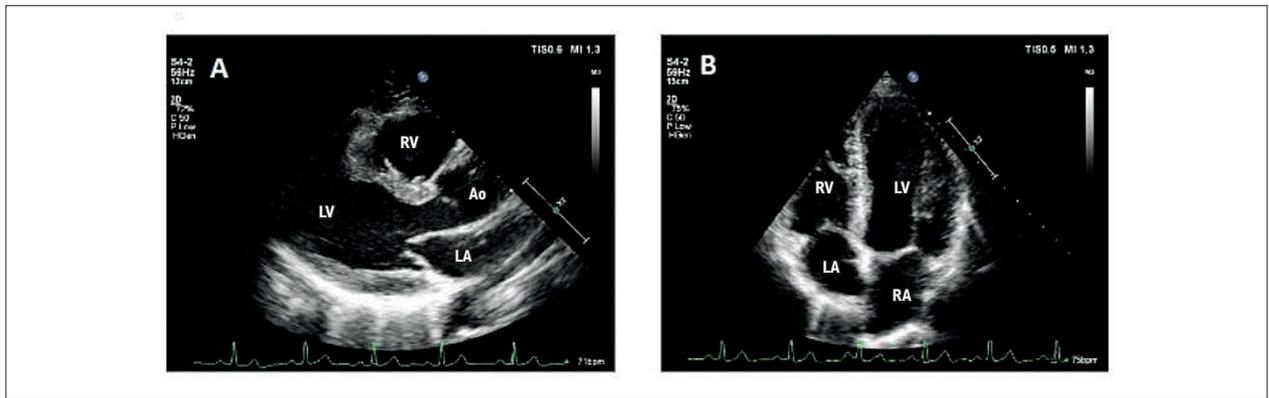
Echocardiographic images in sections: A) Parasternal longitudinal; B) Apical four-chamber view. Key: LV: left ventricle; LA: left atrium; RV: right ventricle; RA: right atrium.
